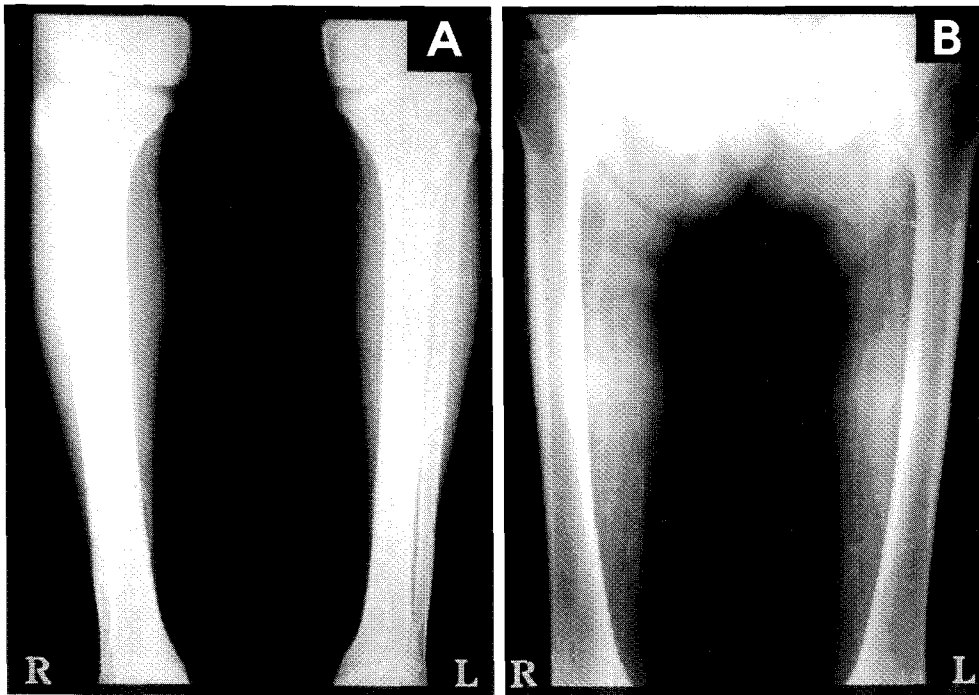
Plain radiography of both femurs (A) and tibias (B) shows extensive calcifications in the femoral and tibial arteries and their branches.
